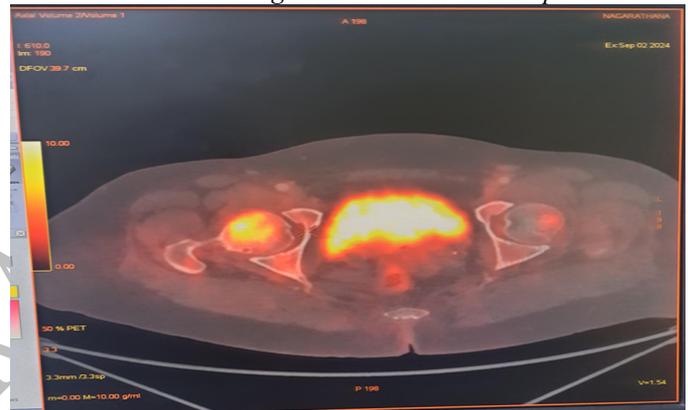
PET-CT image showing FDG avid skeletal lesions involving bilateral acetabulae & femur
